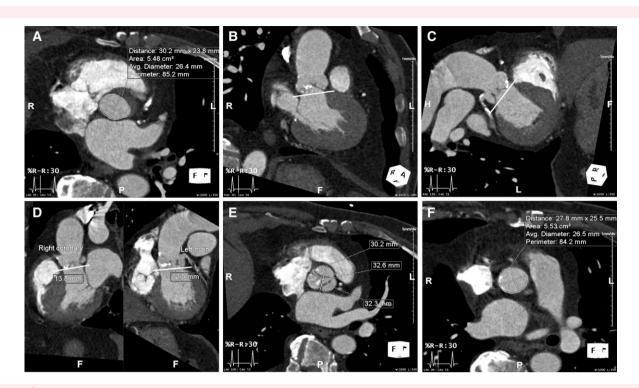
CTA-derived aortic valve reconstructions. (A) Mean annular diameter: 26.4 mm; annular area: 548 mm2 and annular perimeter: 85.2 mm. (B and C) Orthogonal multiplanar reconstructions of the annular plane (D) Left and right coronary artery ostium height. (E) Sinus of Valsalva dimensions. (F) Sinotubular junction measurements.
